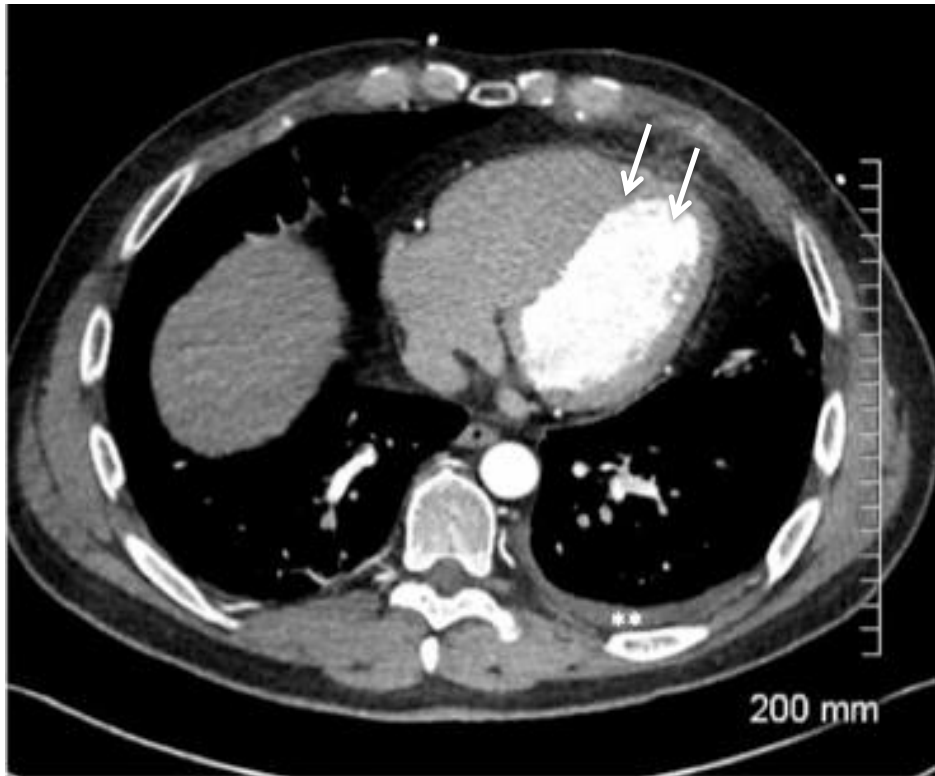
Axial CT scan depicts also left pleural effusion (asterisk) in addition to pericardial changes (arrows).
